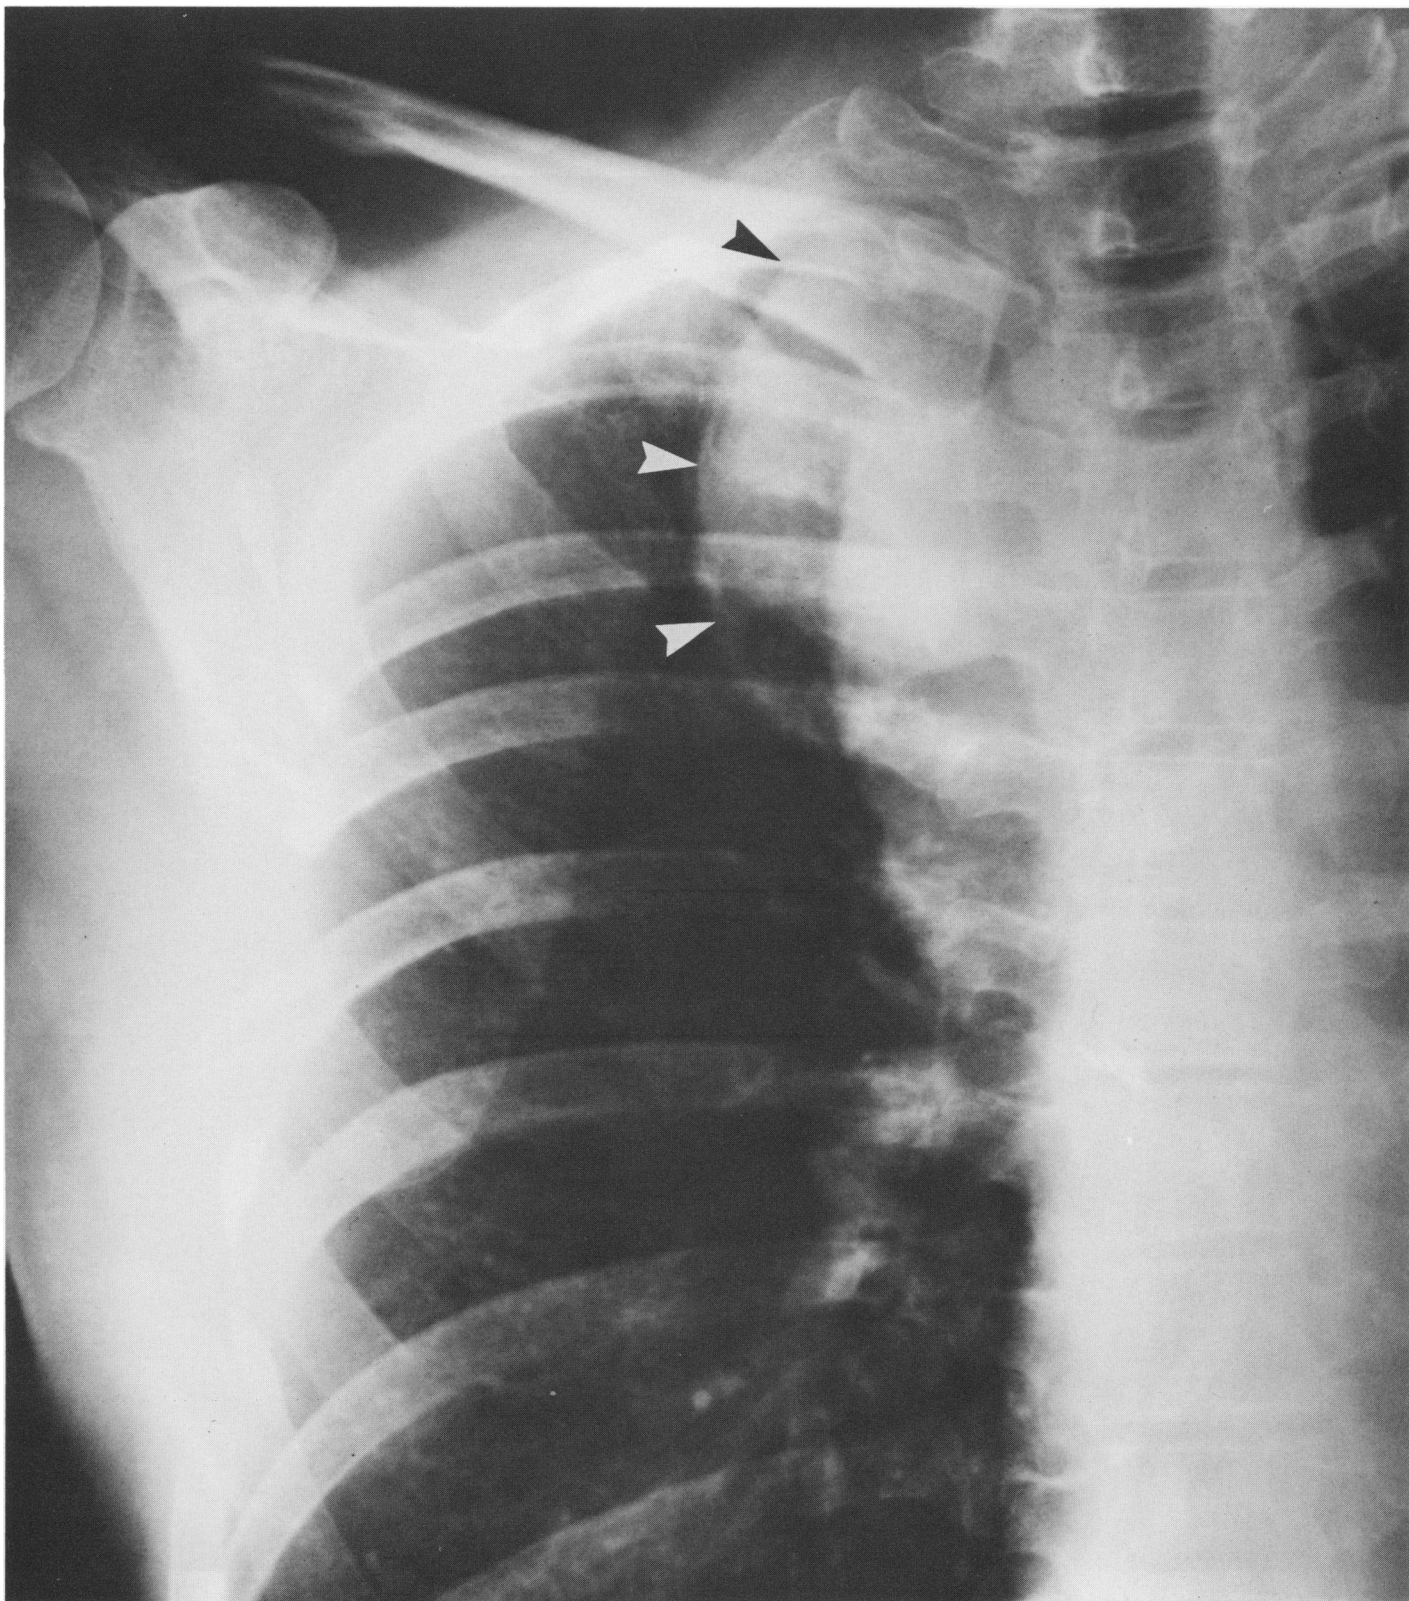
Anteroposterior rib radiograph shows a mass in the upper lung field. (arrows)
